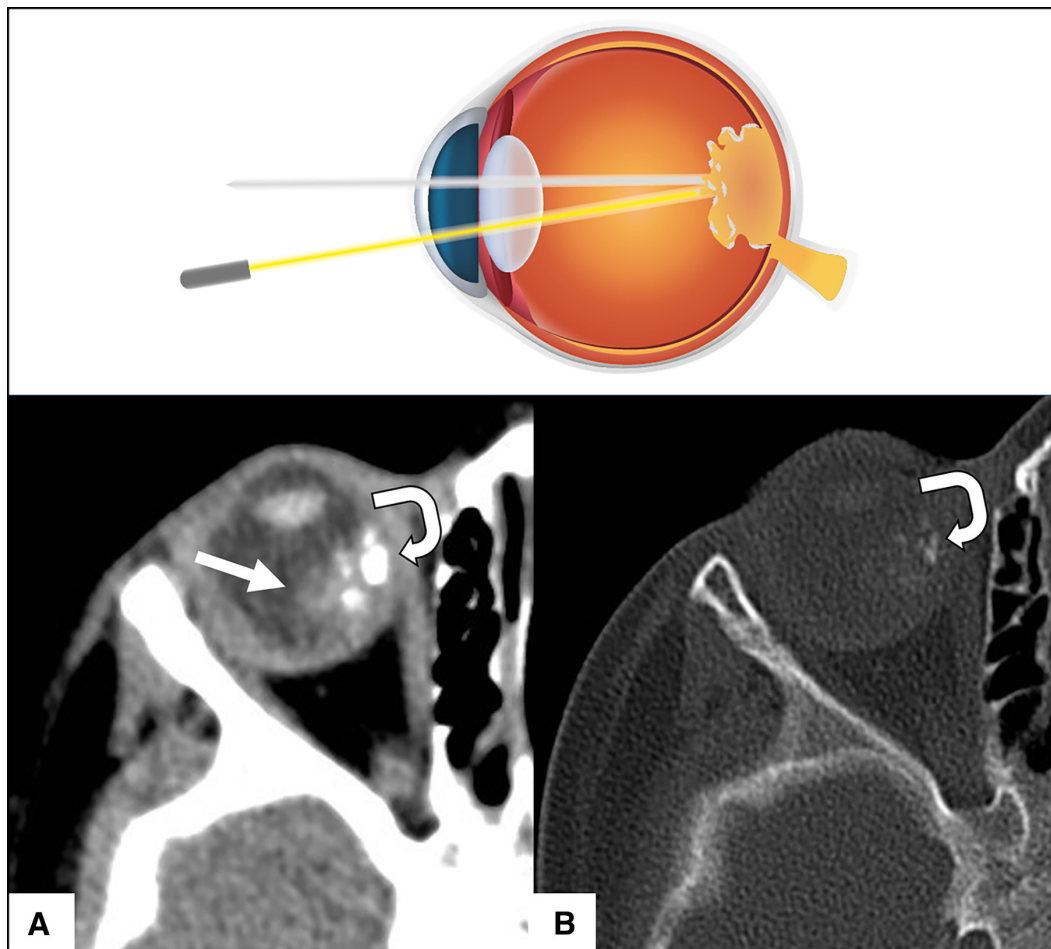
Retinoblastoma of the right eye. Axial images from a noncontrast CT in a soft-tissue kernel (A) and bone kernel (B) show a hyperdense intraocular mass (white arrow) with calcifications (curved arrows), compatible with retinoblastoma.
